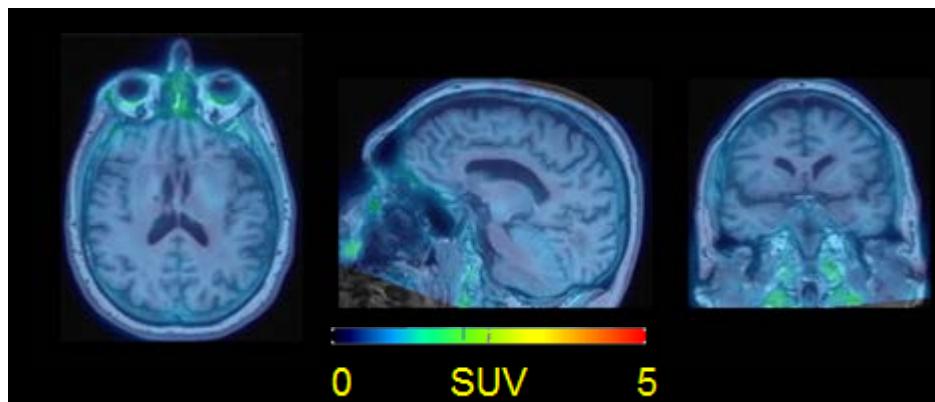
Average PET Image (60 – 90 min) Overlaid on MRI from a 68 Year Old Healthy Male Subject Injected with 155 MBq of ^{18}F -MK-6240. The color scale for PET image is shown in terms of standardized uptake value (SUV) that is normalized to injected radioactivity and body weight.
